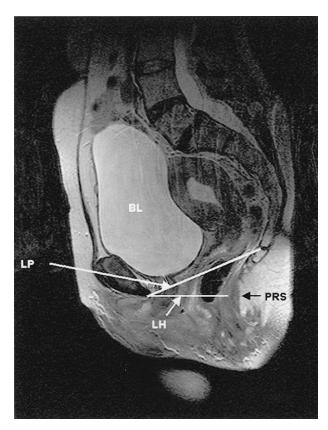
Midsagittal phased-array MRI of the pelvis showing components of the levator and anal sphincter complex, levator plate "pubococcygeal line" (*LP*), levator hiatus (*LH*), and puborectalis sling (*PRS*). BL = urinary bladder.
